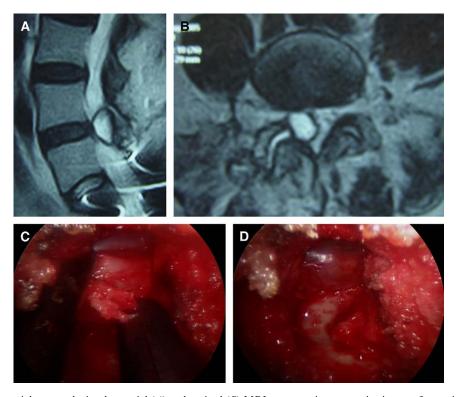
Synovial cyst as depicted on axial (A) and sagittal (B) MRI scans, an intraoperative image of synovial cyst resection (C), and complete removal of cyst (D).
